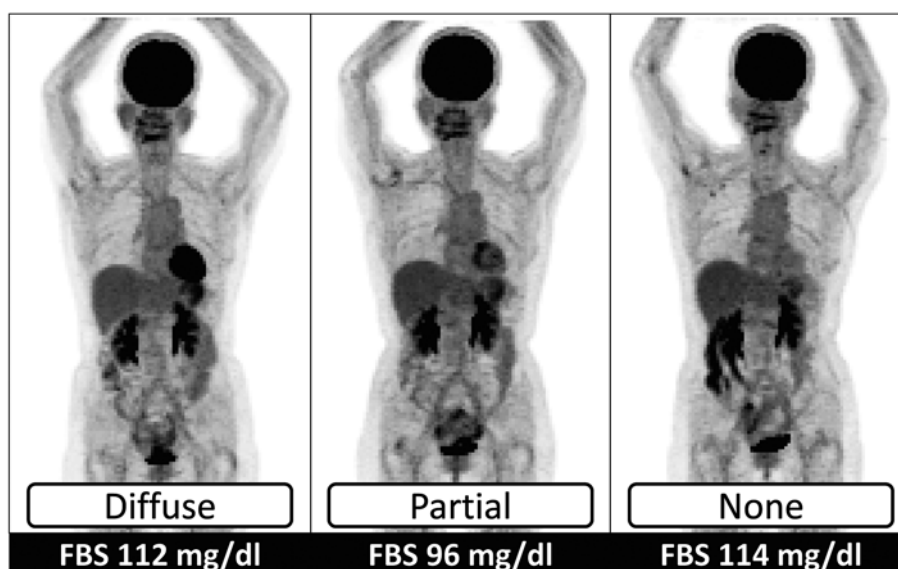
Physiological myocardial ¹⁸F-FDG uptake in patients with malignant lymphoma without heart disease. This patient underwent two fasting ¹⁸F-FDG PET/CT studies. The myocardial ¹⁸F-FDG uptake showed various patterns and was not associated with fasting blood sugar level.
